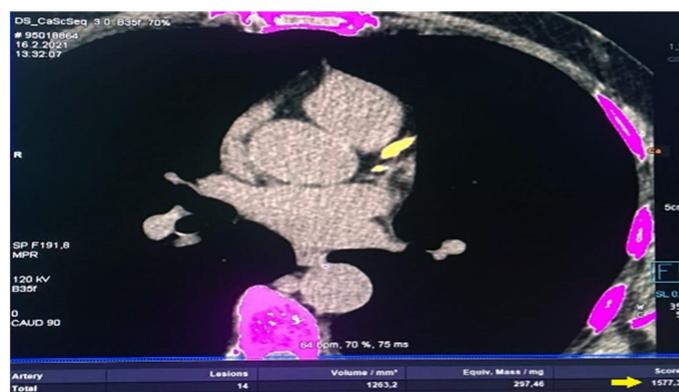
Asymptomatic 64-year-old hypertensive patient with 11% (intermediate) 10-year ASCVD risk. LDL is 150 mg/dL. Total CAC score is 1577 Agatston Units (yellow arrow). The patient agreed to start statin therapy after seeing their CAC score picture. This image is from my Cardiac CT archive; the video was submitted to view the full part of the CAC score.
